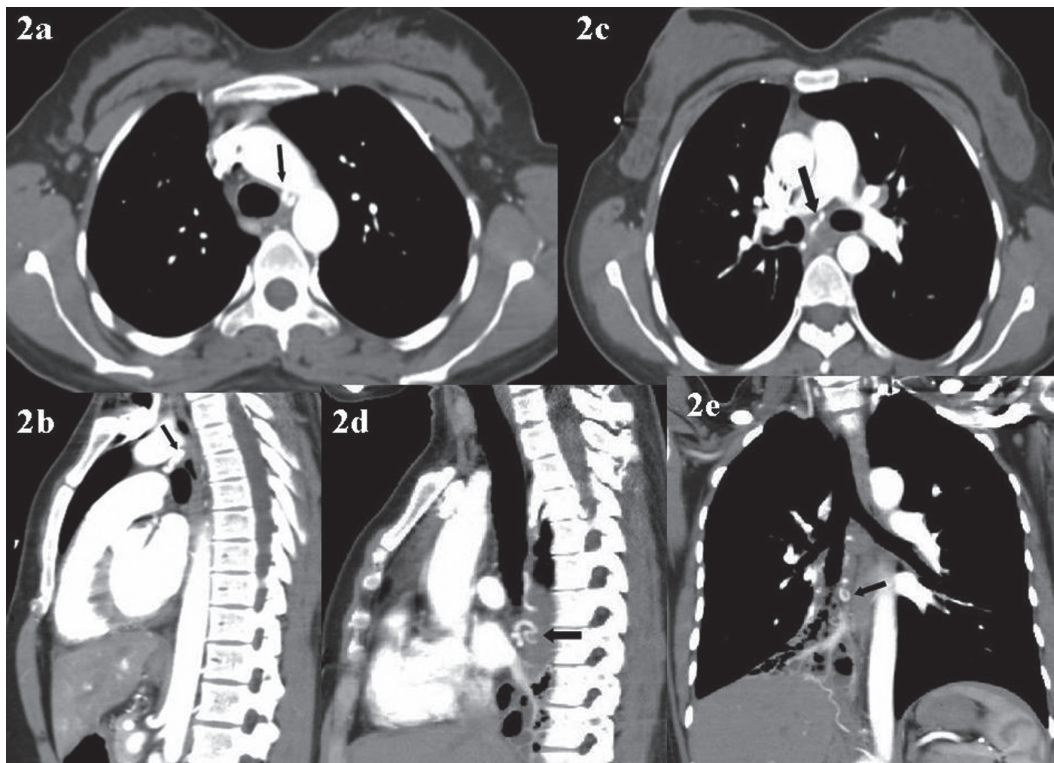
(a) Transverse reconstructive image of thoracic CT scan shows the aberrant vascular structure originating from aortic arc (arrow). (b) Sagittal reconstructive image of thoracic CT scan shows the aberrant vascular structure originating from aortic arc (arrow). (c) In transverse reconstruction, this vessel extends to the pulmonary sequestration (arrow). (d) In sagittal reconstruction, this vessel extends to the pulmonary sequestration (arrow). (e) In coronal reconstruction, this vessel extends to the pulmonary sequestration (arrow).
